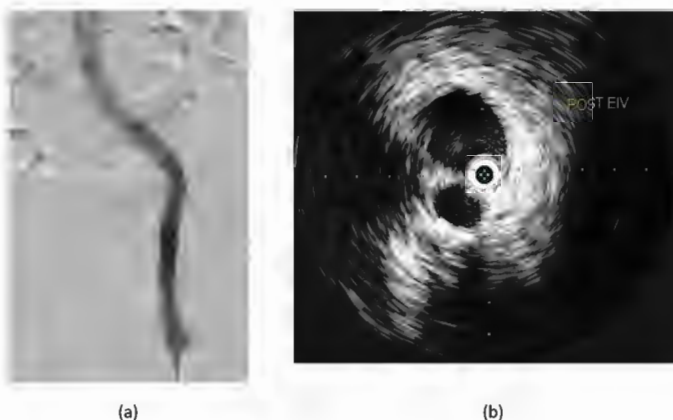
(a) Establishment of venous patency and inline flow after aspiration mechanical thrombectomy on venography, (b) Intravascular ultrasound demonstrating clearance of thrombus from the external iliac vein after aspiration mechanical thrombectomy with Indigo system.
